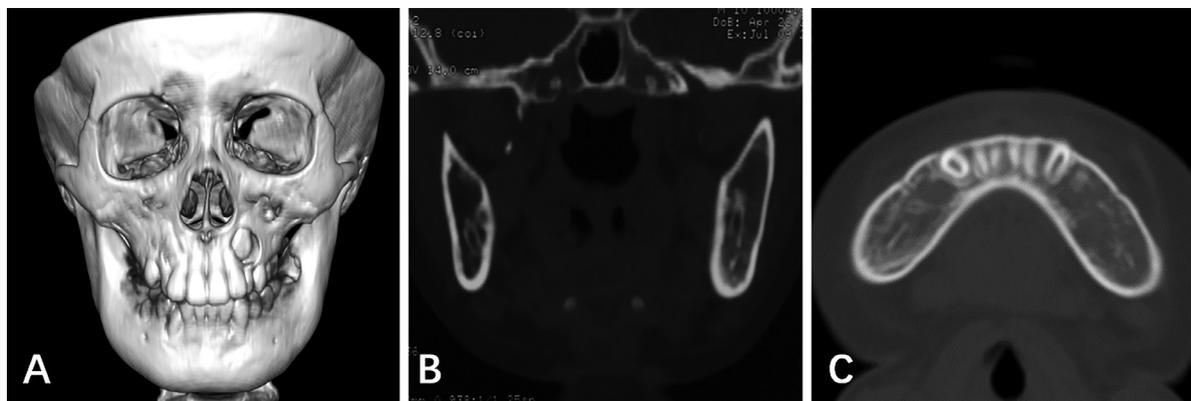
Computed tomography (CT) images at 12 months after treatment, showing a smooth mandibular surface and decreased volume of the affected mandibular region. The bone cortex and the cancellous substance of the mandible are almost normal.
